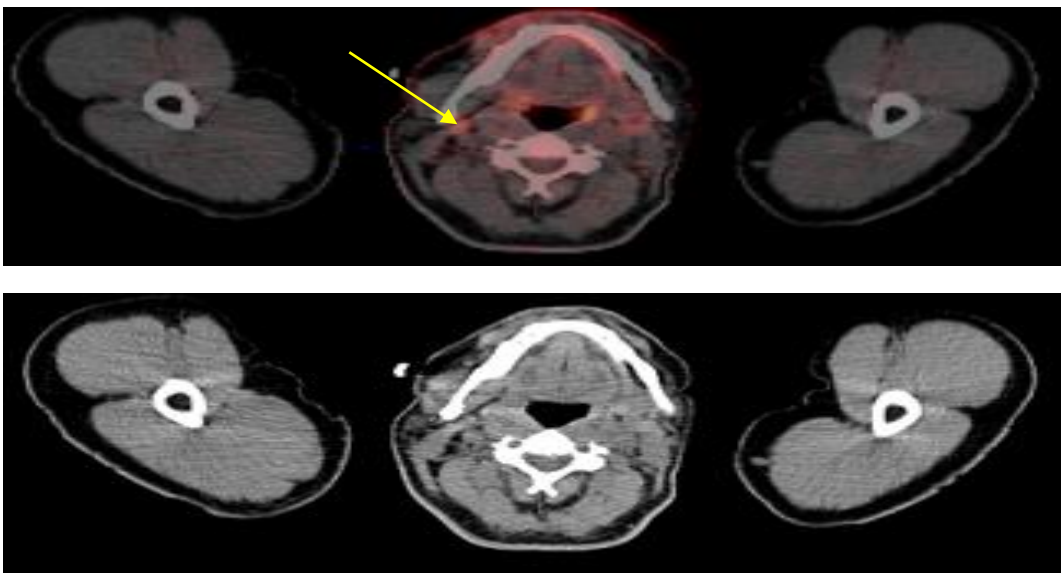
60-year-old patient with pancreatic undifferentiated carcinoma. PET/CT showed right cervical lymph node that measured 1.2 cm with SUVmax 5. Biopsy revealed metastatic undifferentiated carcinoma.
